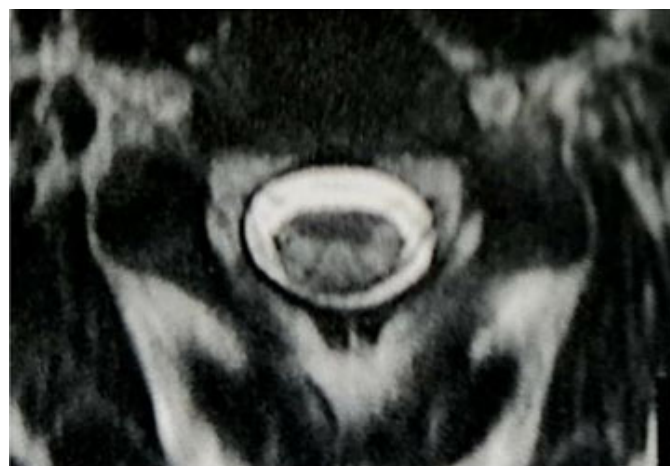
Cervical MRI—axial view—Presentation of hyperintense signal on T2 at dorsal columns and lateral corticospinal tracts.
